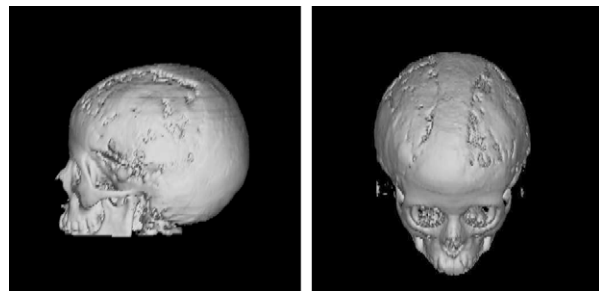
Same patient; 3-D-CT scans: two views of widespread calvarial bone defects three months postoperatively.
